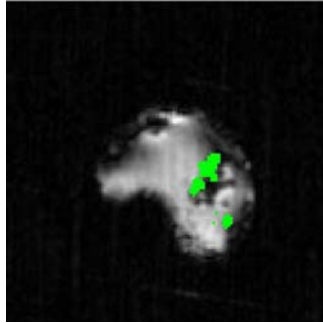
Overlay of ^{19}F and ^1H MR images. It demonstrated that HFB was distributed in both central and peripheral regions of tumors.
